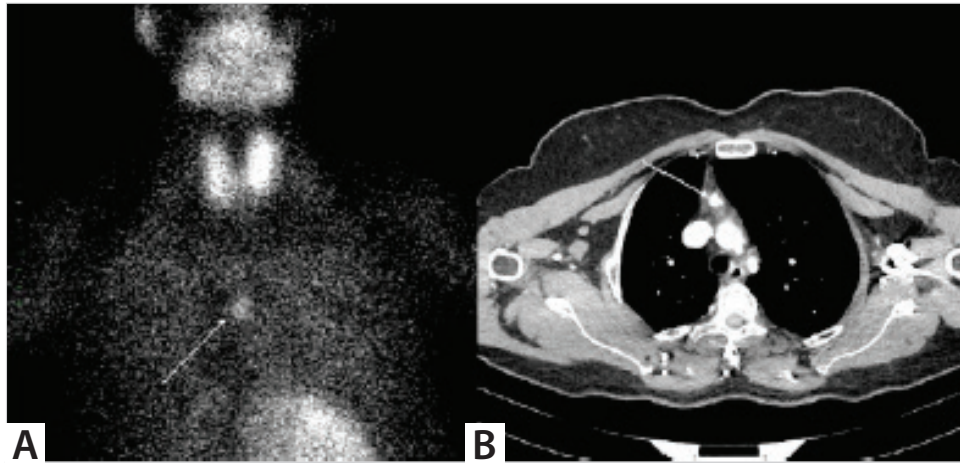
A. Ectopic mediastinal parathyroid adenoma (white arrow), Technetium-99m-sestamibi scintigraphy image. B. 4D-CT axial section image of ectopic mediastinal parathyroid adenoma (white arrow).
